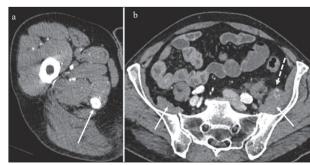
Axial contrast-enhanced CT metastatic type I lesion, presented as oval-shaped lesions, with homogenous enhancement (a) in the right adductor magnus muscle (arrow), (b) type II lesion (dotted arrow), and type III (arrow) in the left iliac muscle; the right iliac muscle without any type of metastases (arrow)
